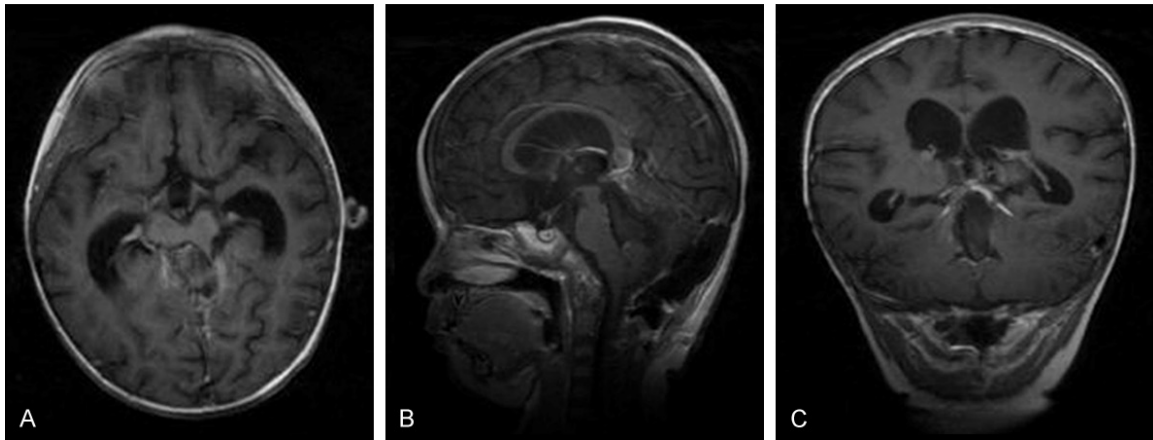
Postoperative MRI scans showing subtotal removal of the mass lesion in 2 years old patient.
